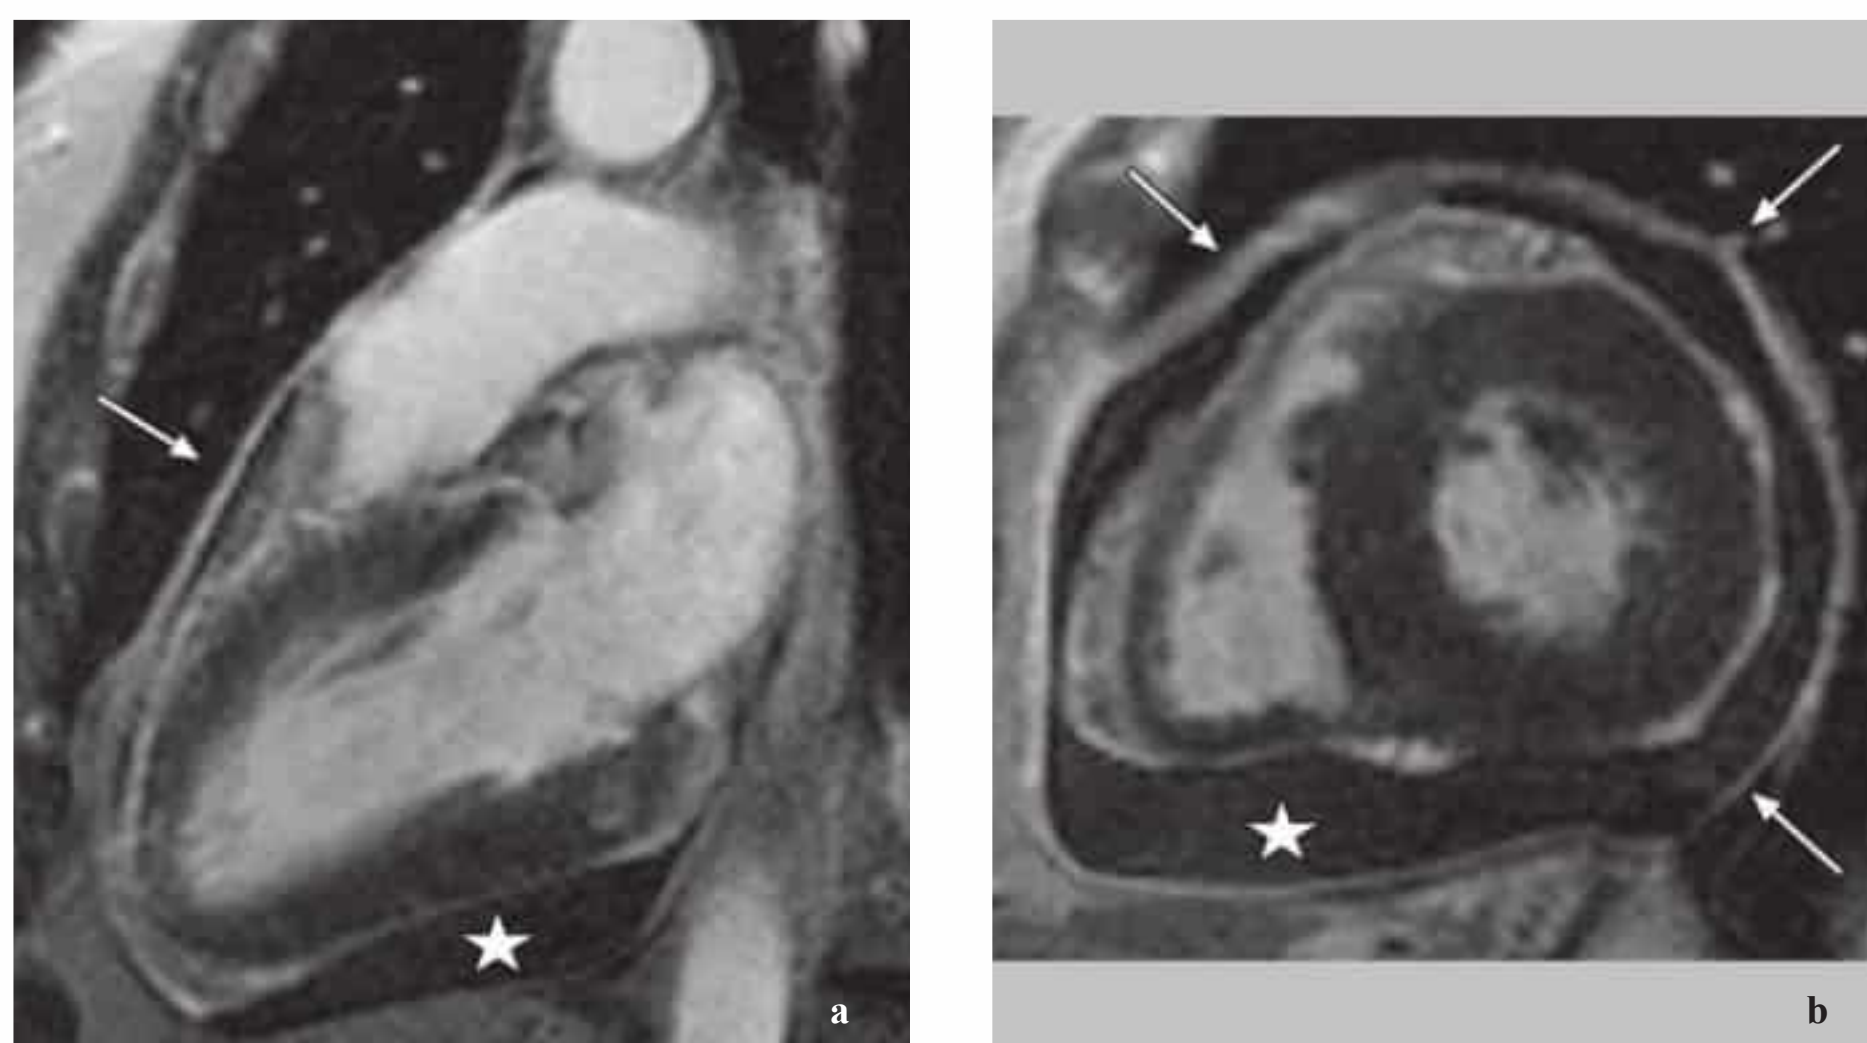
a, b Contrast-enhanced T1-weighted MR images of a large pericardial effusion (star) in acute pericarditis. Note the contrast enhancement in the pericardium (arrows).
